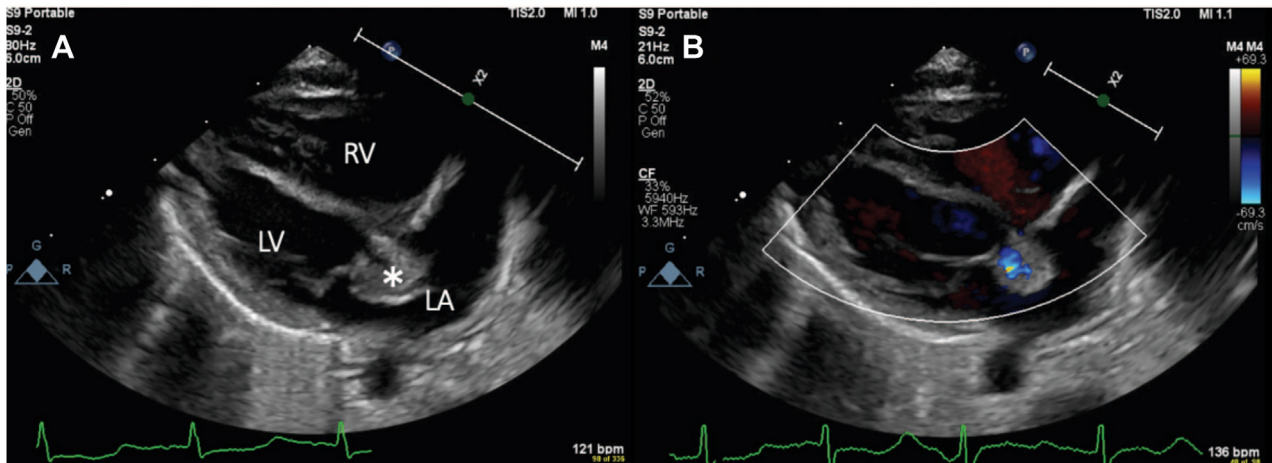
(A) Two-dimensional parasternal long-axis view, in systole, on postnatal transthoracic echocardiography on the first day of life showing the P-MAIVF (*asterisk*) originating between the aortic and mitral valves (B), with color Doppler showing flow into the P-MAIVF in systole in the parasternal long axis view. *Asterisk* indicates P-MAIVF. LA, Left atrium; LV, left ventricle; RV, right ventricle.
